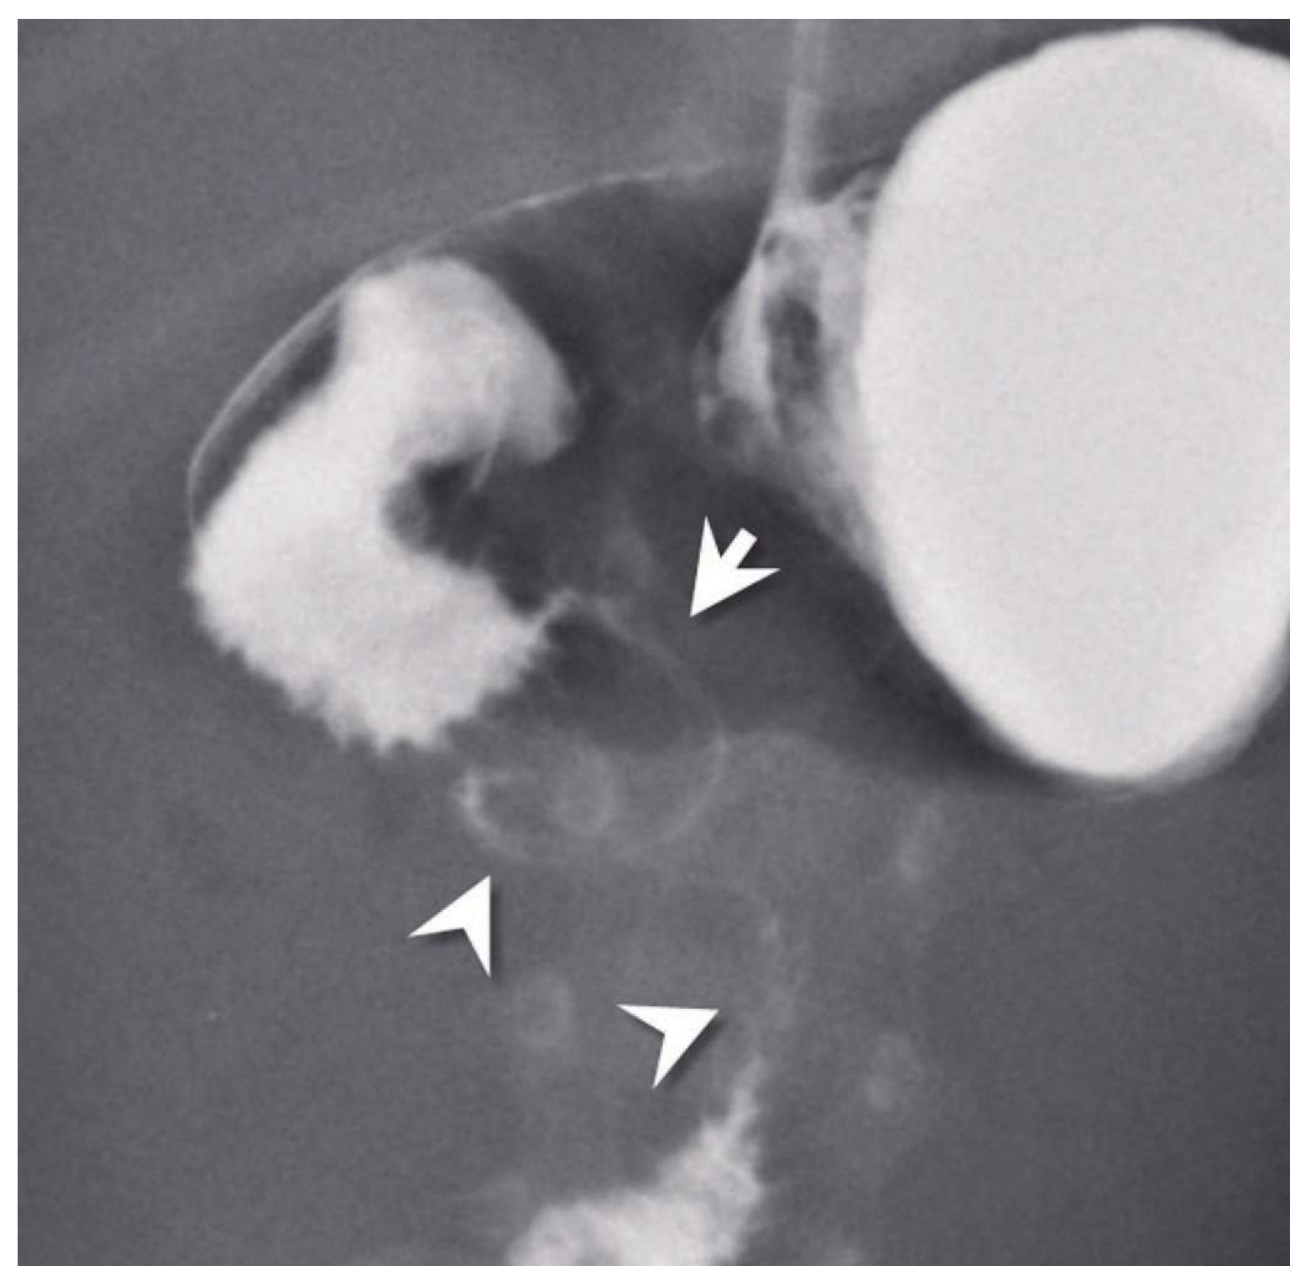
■ Intestinal Malrotation with Volvulus. Anteroposterior radiograph from an upper GI series shows malrotation with midgut volvulus. The duodenum (arrowheads) does not cross midline and does not extend superiorly to the level of the pylorus. The spiraling downward appearance is consistent with volvulus. (Photo contributor: Alexander Towbin, MD.)
